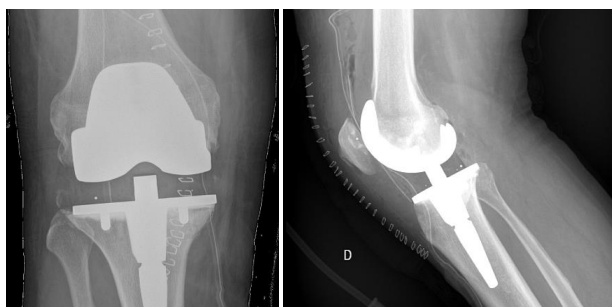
g-h. — Radiographs after revising the partial knee prosthesis for a total knee prosthesis (Persona®, Zimmer-Biomet, Warsaw USA).
